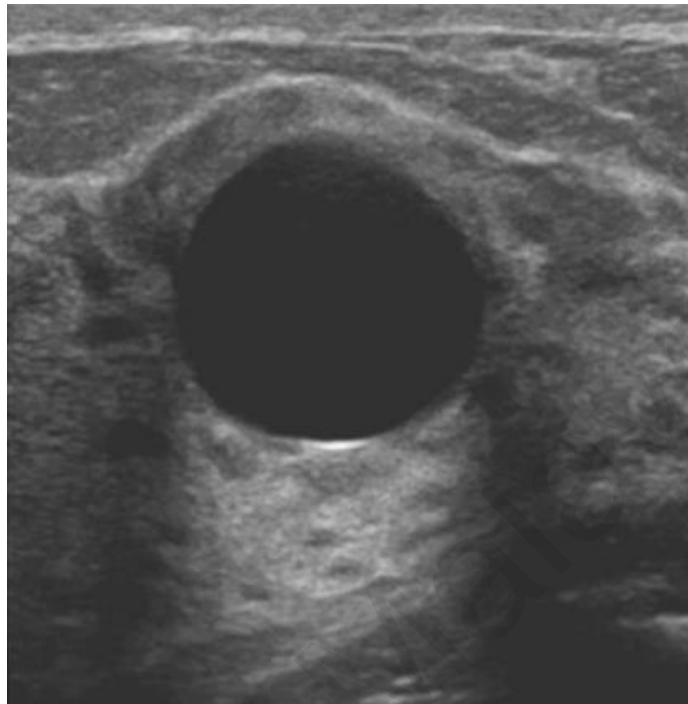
Identification of a lump, mass, or cyst by the absence of internal echoes and the posterior enhancement of the ultrasound beam (James et al. 2016)
